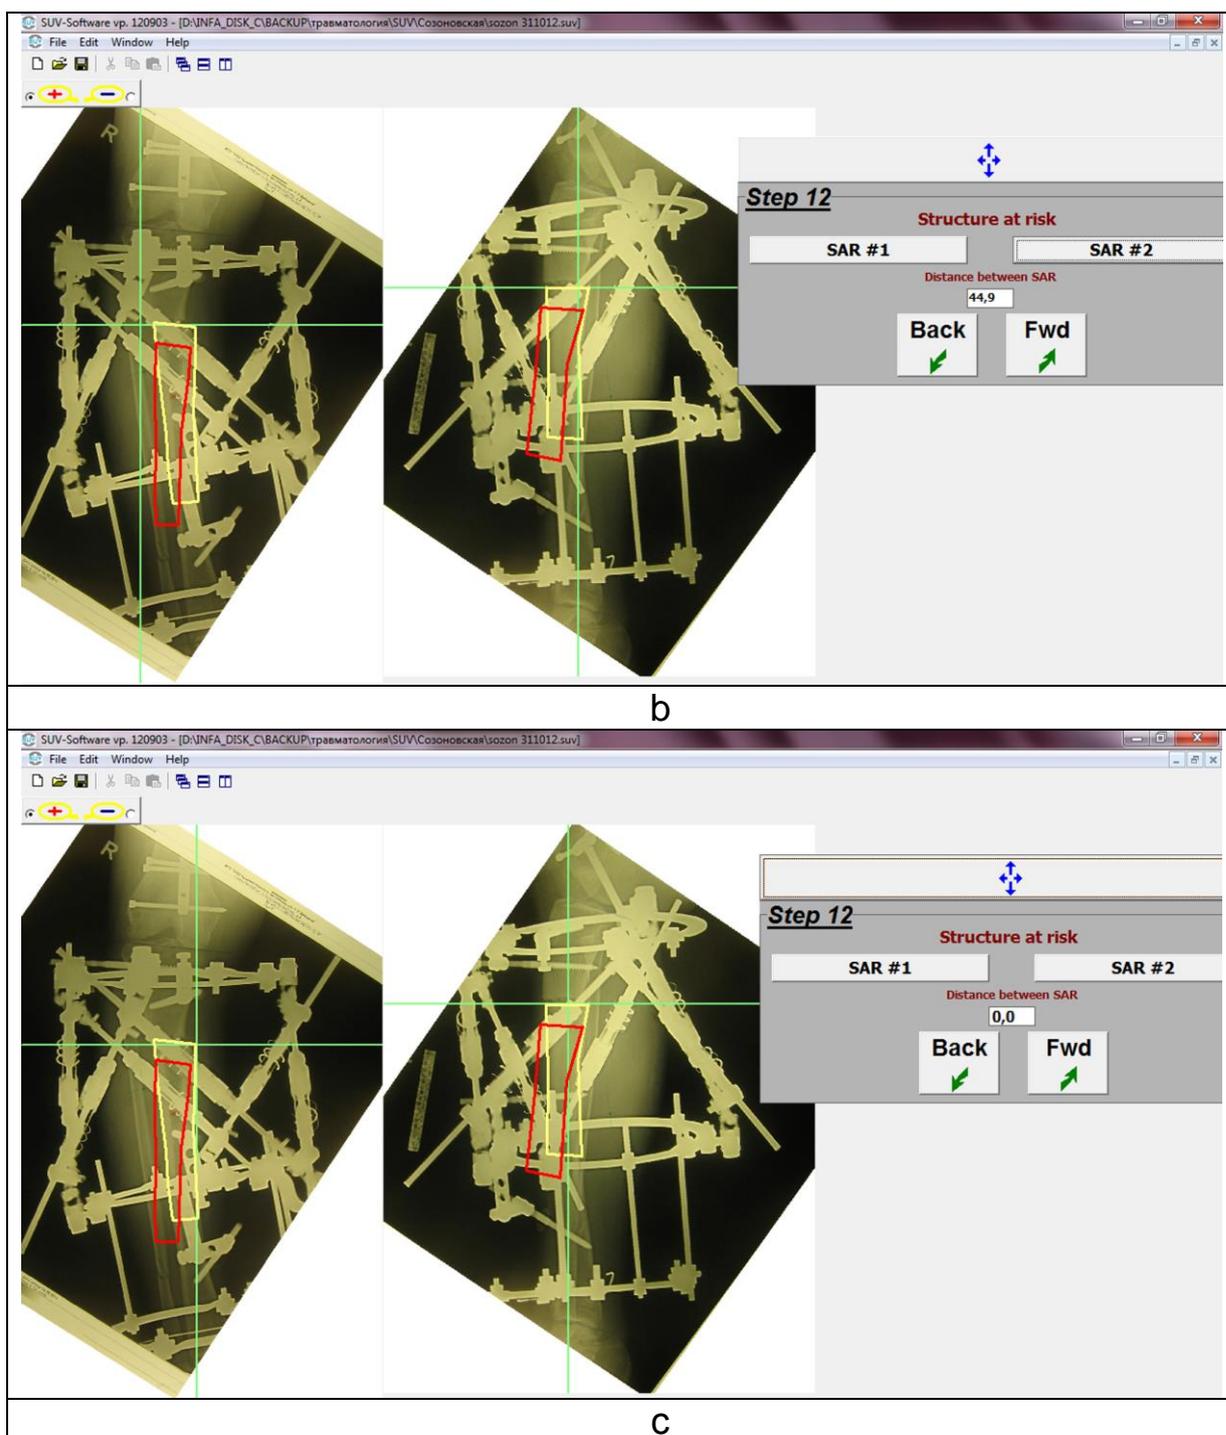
Ortho-SUV program window in Step 12: identification of structures at risk - SAR. a - SAR #1 on AP and Lat view is marked by the tool "green cross". It must be the same point! After that button "SAR #1" is being pressed. b - SAR #2 on AP and Lat view is marked by the tool "green cross". It must be the same point! After that button "SAR #2" is being pressed. In window "Distance between SAR" figure 44.9 has appeared. It is distance between SAR in mm. c – it was decided to ignore SAR #2. For this purpose after designation of SAR #1 button SAR #2 should immediately be pressed. After that in the window "Distance between SAR" digit "0" has appeared. For the program it means SAR #1 and SAR #2 coincide.
